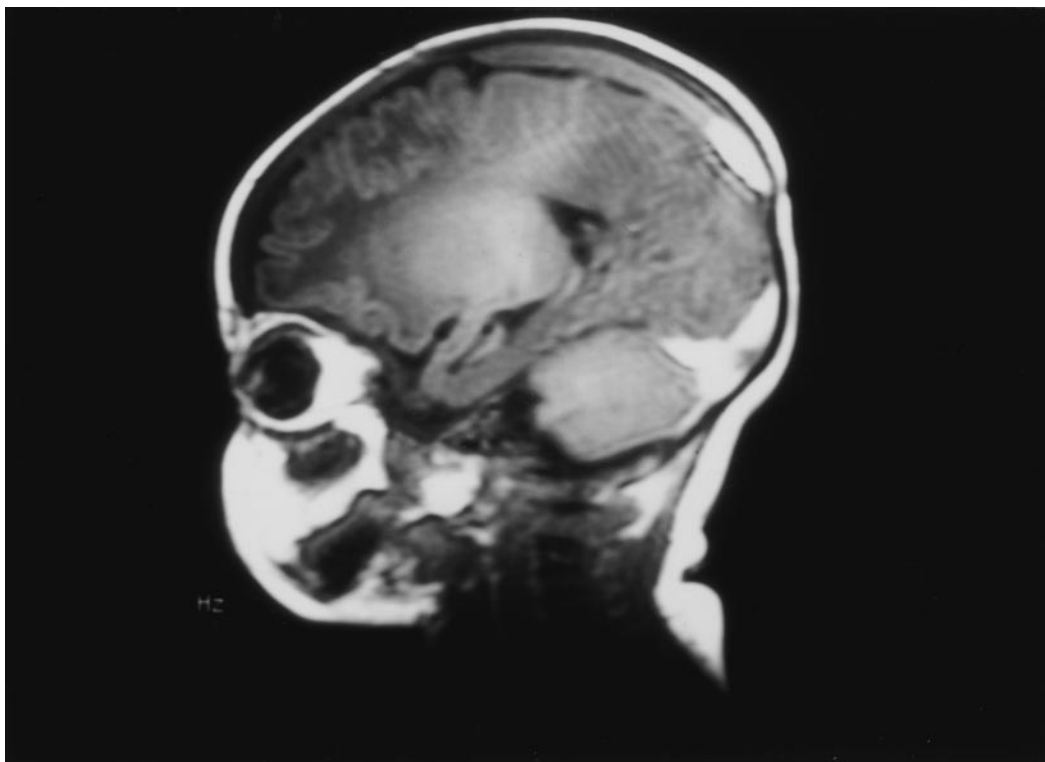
In patient 7, MRI showed subdural hematomas of different ages.
